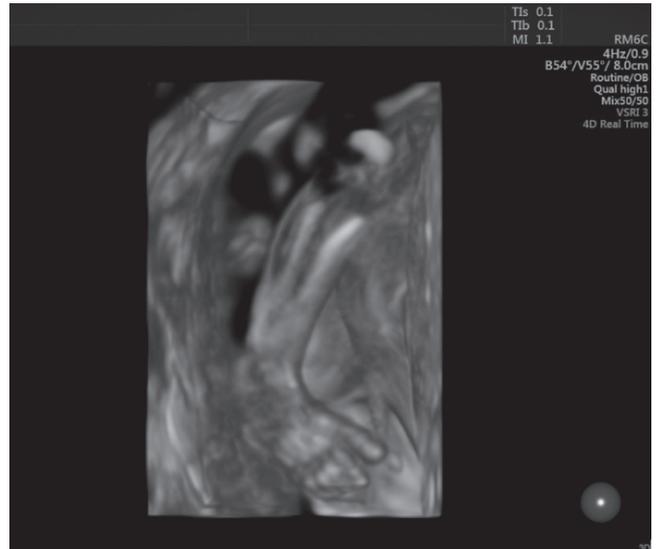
Three-dimensional ultrasound evaluation of the fetal left lower limb revealed trisegmental limb normally structured and left foot with five toes in valgus position.
